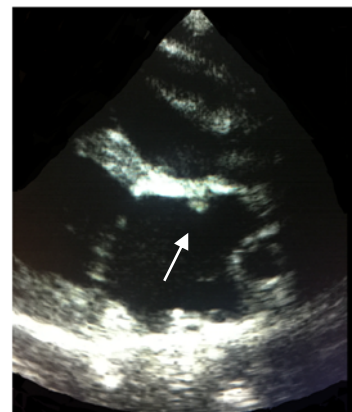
Echocardiograph. Vegetative fossa ovale lesion.
